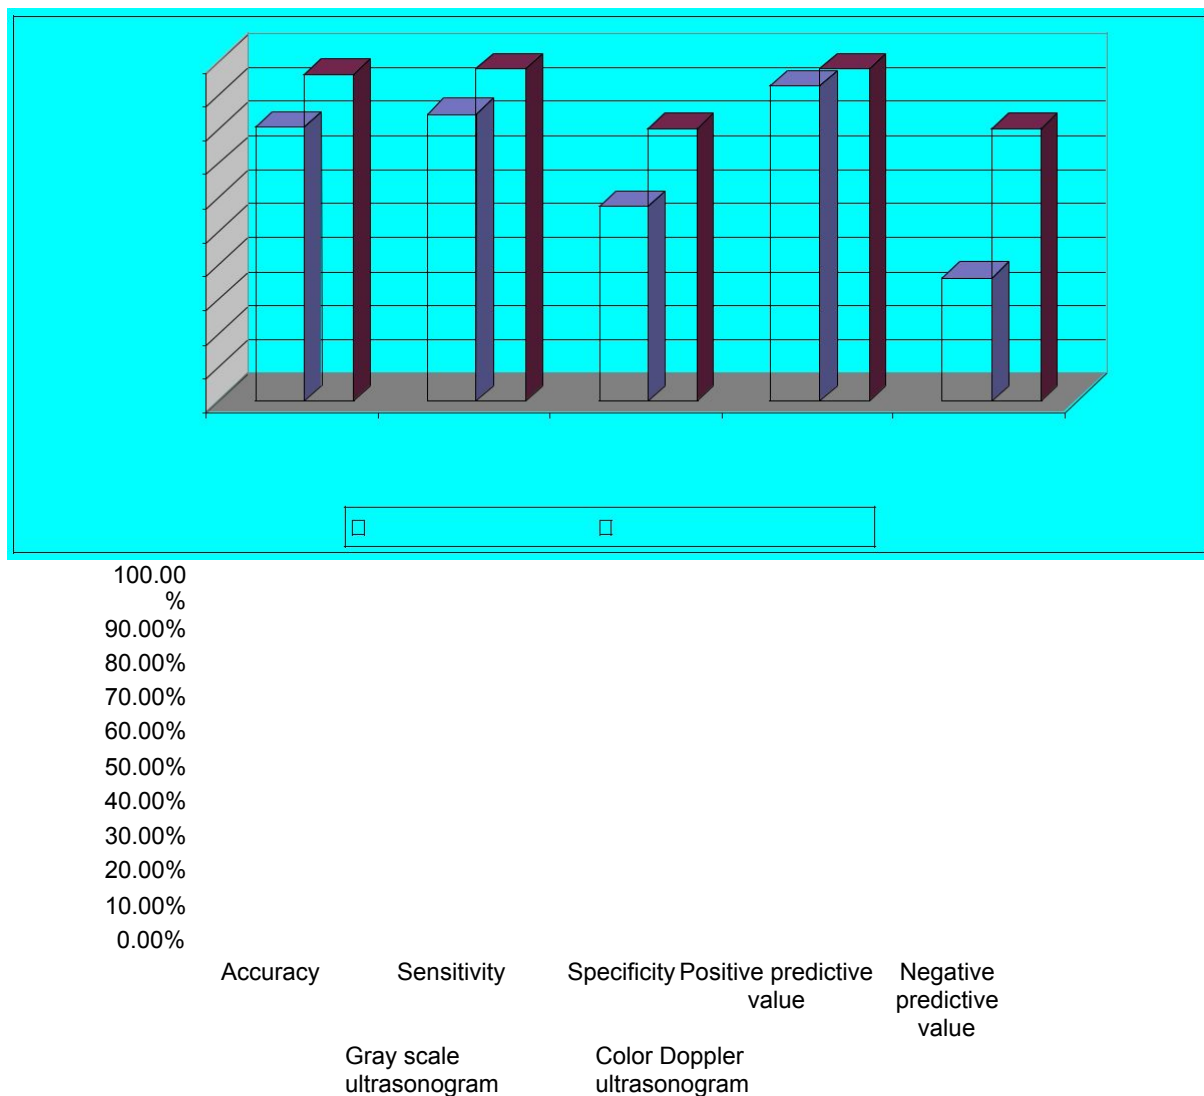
Showing comparative study of Accuracy, Sensitivity, Specificity, Positive & Negative predictive values of Gray scale imaging & Color Doppler imaging in the diagnosis of different intrascrotal diseases.
